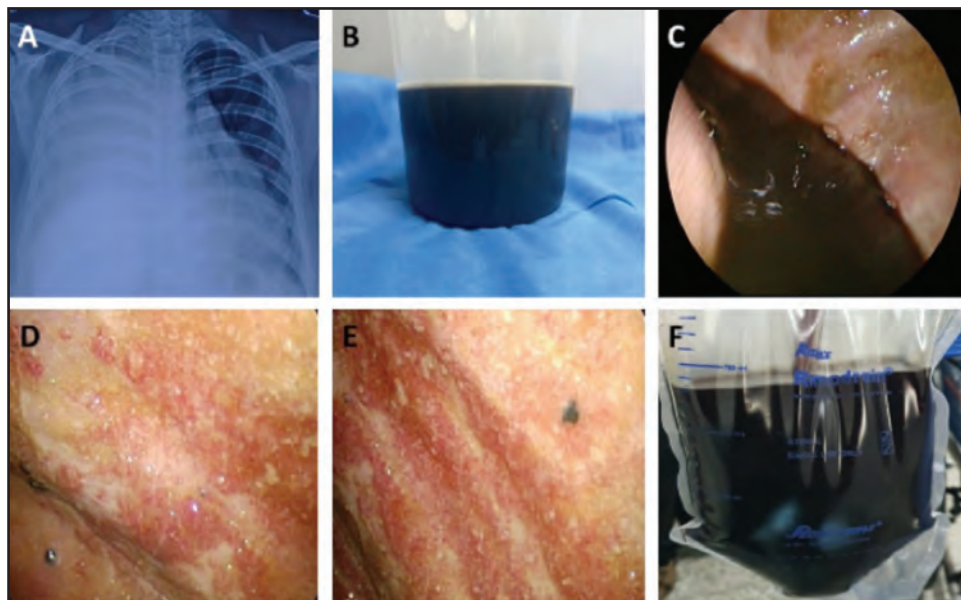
A) Chest x-ray (PA view) showing complete white out right hemithorax with contralateral mediastinal shift. B) Black coloured pleural fluid obtained during diagnostic thoracentesis. C) Black coloured pleural fluid visualised within the pleural cavity during medical thoracoscopy. D), E) Dull, thickened pleura with diffuse, yellow-coloured plaques and multiple small nodules seen on medical thoracoscopy. F) Black coloured pleural fluid collected in under water seal bag, connected to intercostal drain.
